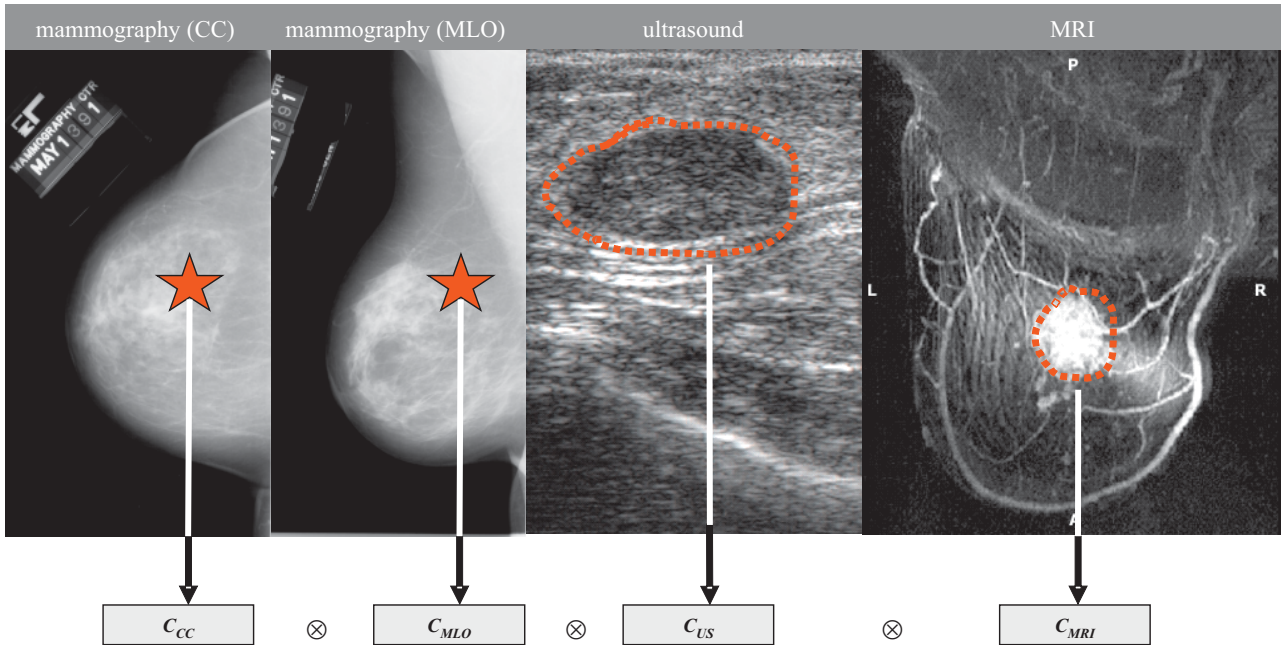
Generation of an extended feature vector characterizing a mass lesion from multiple modalities, including the craniocaudal (CC) and mediolateral-oblique (MLO) projections of mammograms, ultrasound and MRI.
